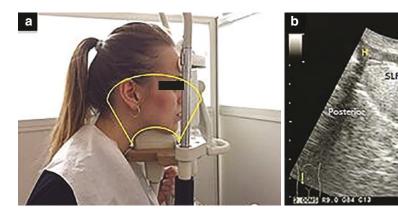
Sagittal view in the submandibular position using a convex transducer between the mentum and the hyoid bone (a). The sonogram shows the tongue and the floor of the mouth (b). The insets show the transducer
